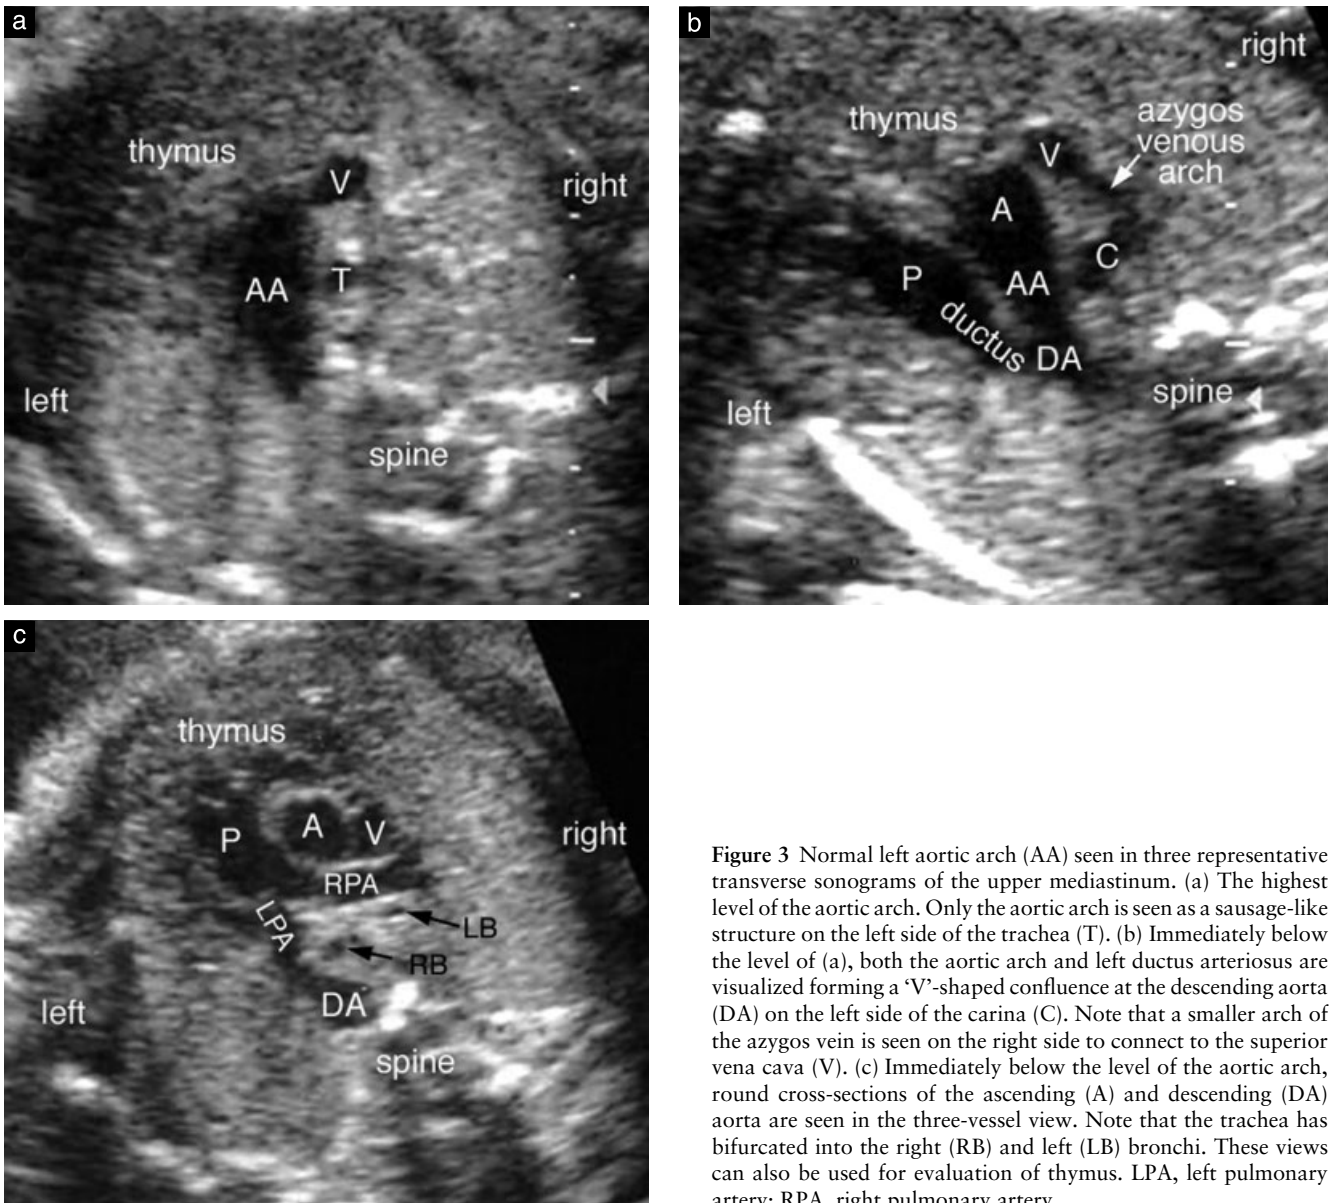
Normal left aortic arch (AA) seen in three representative transverse sonograms of the upper mediastinum. (a) The highest level of the aortic arch. Only the aortic arch is seen as a sausage-like structure on the left side of the trachea (T). (b) Immediately below the level of (a), both the aortic arch and left ductus arteriosus are visualized forming a 'V'-shaped confluence at the descending aorta (DA) on the left side of the carina (C). Note that a smaller arch of the azygos vein is seen on the right side to connect to the superior vena cava (V). (c) Immediately below the level of the aortic arch, round cross-sections of the ascending (A) and descending (DA) aorta are seen in the three-vessel view. Note that the trachea has bifurcated into the right (RB) and left (LB) bronchi. These views can also be used for evaluation of thymus. LPA, left pulmonary artery; RPA, right pulmonary artery.
